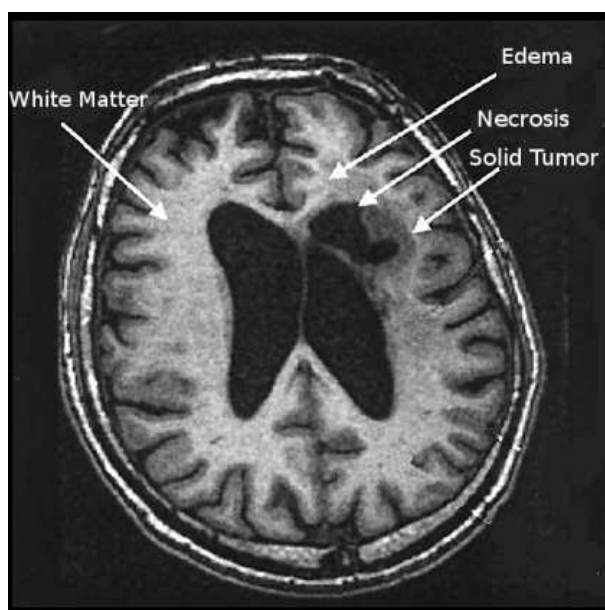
One axial slice of a MR image of the brain showing tumor areas [Mahmoud-Ghoneima et al., 2003].
